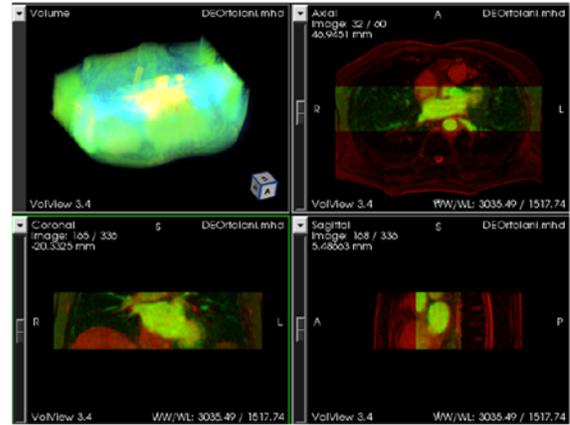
Result of the affine registration in one patient in three orthogonal planes. In red we show the MRA images, in green the DE-MR images.
